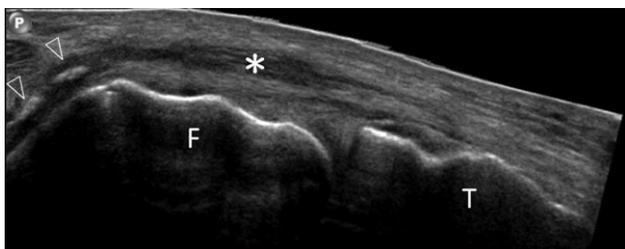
Ultrasound image from the painful medial knee of a 43-year-old woman after stream tracing, showing hypoechoic thickening (*) at superficial component of medial collateral ligament (MCL). Avulsion fractures (open arrowheads) are noted at its proximal insertion to the femur (F). T = tibia.
